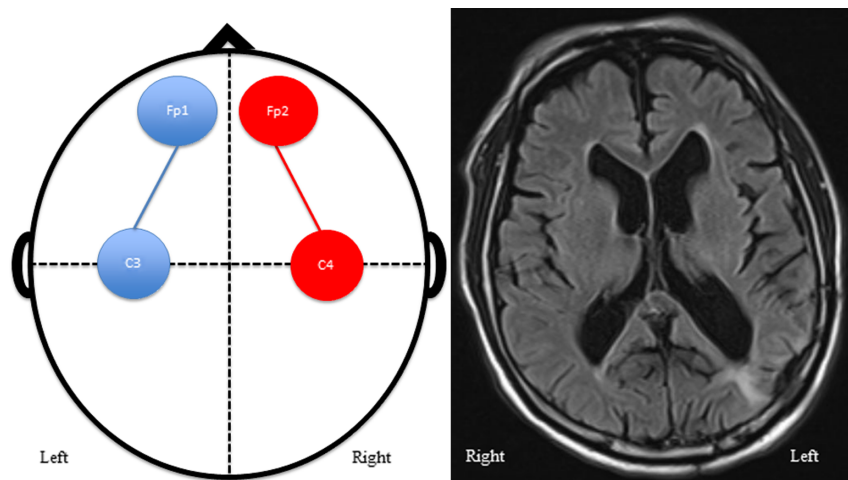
Baseline cerebral status and diagnostic strategy. Left panel, configuration of the bedside two-channel amplitude-integrated electroencephalography device: FP1-C3 and FP2-C2. Right panel, magnetic resonance imaging with fluid attenuation inversion recovery in a 66-year-old man diagnosed with non-convulsive status epilepticus. The high-density area located in the left occipital lobe reflects a previous surgery for meningioma resection.
